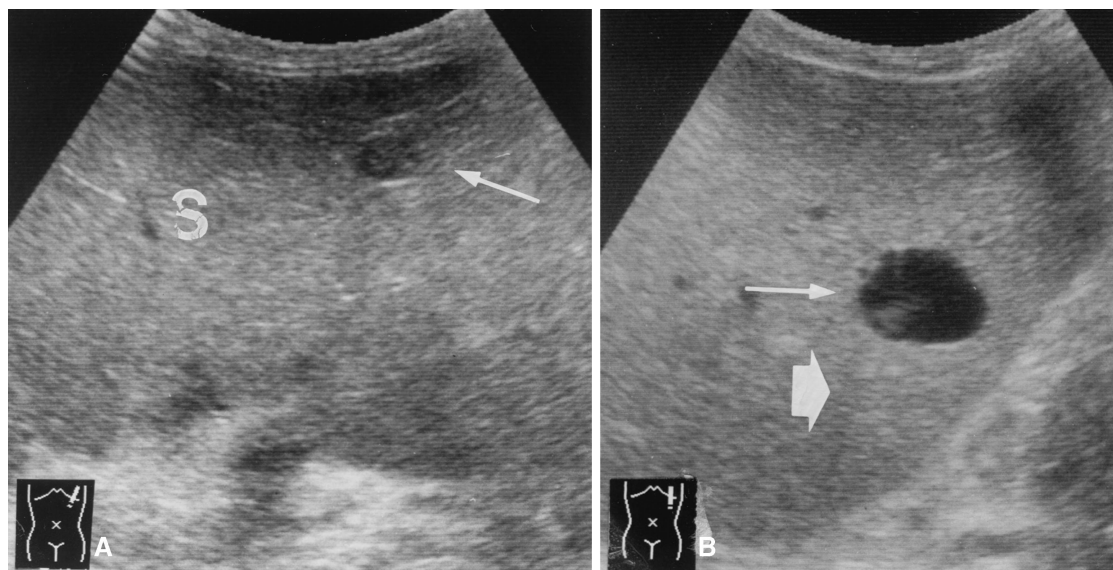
Sonograms of splenic cysts. A A hypoechoic lesion with a distinct boundary (*arrow*) in the spleen (*S*). B An anechoic lesion
